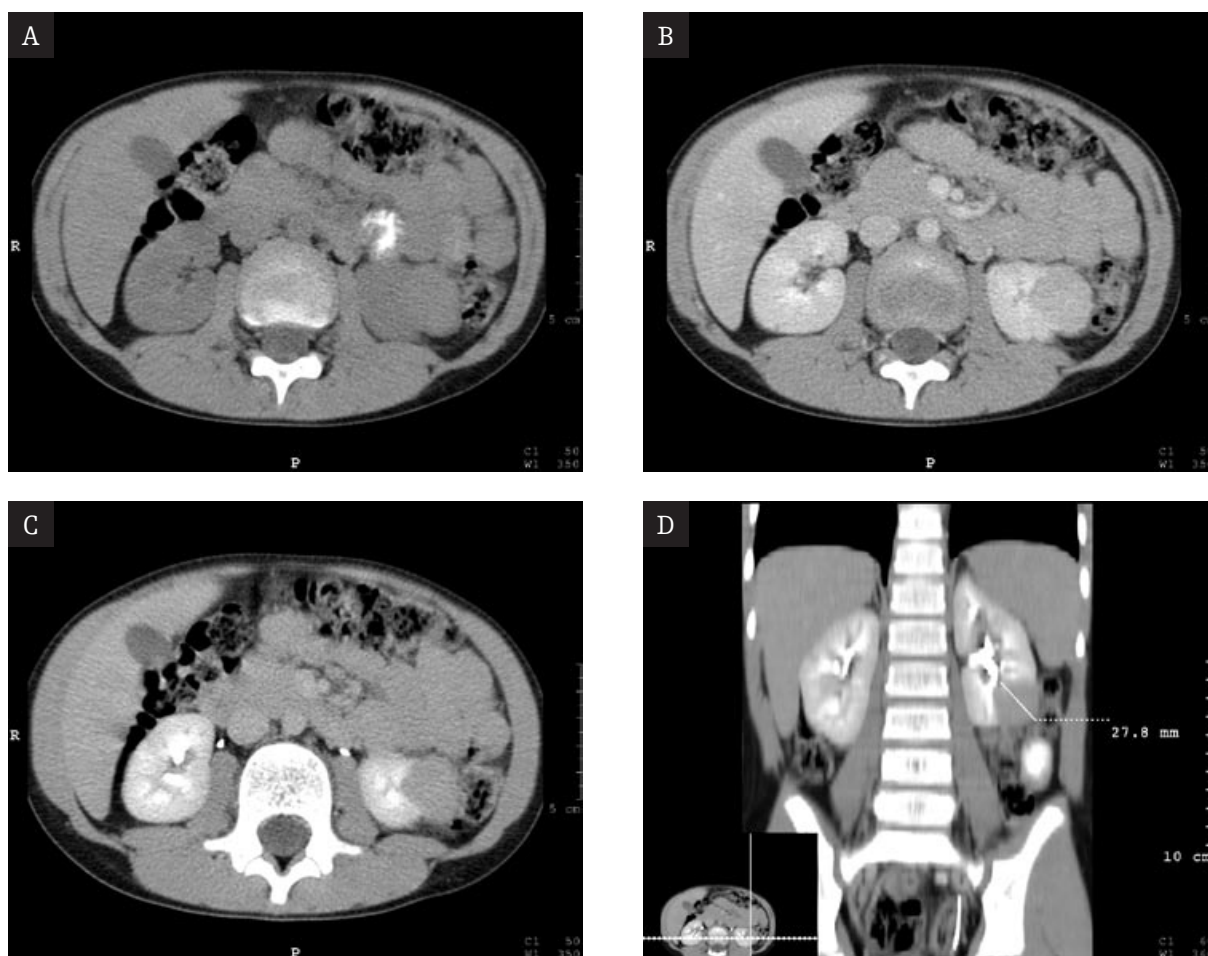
CT image of the low-fat angiomyolipoma: A – before contrast administration, B – parenchymal phase, C – excretory phase, D – MPR reconstruction in the frontal plane.
